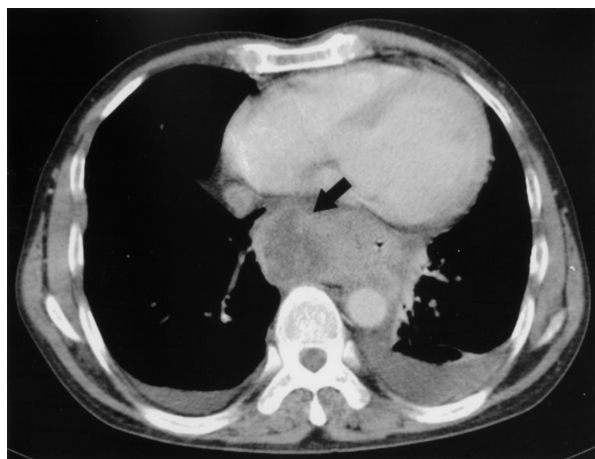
Abdominal computed tomography scan revealed an ulcerative mass lesion about 7.0 cm in diameter in the esophagus (arrow) with extensive mediastinal lymphadenopathy.
